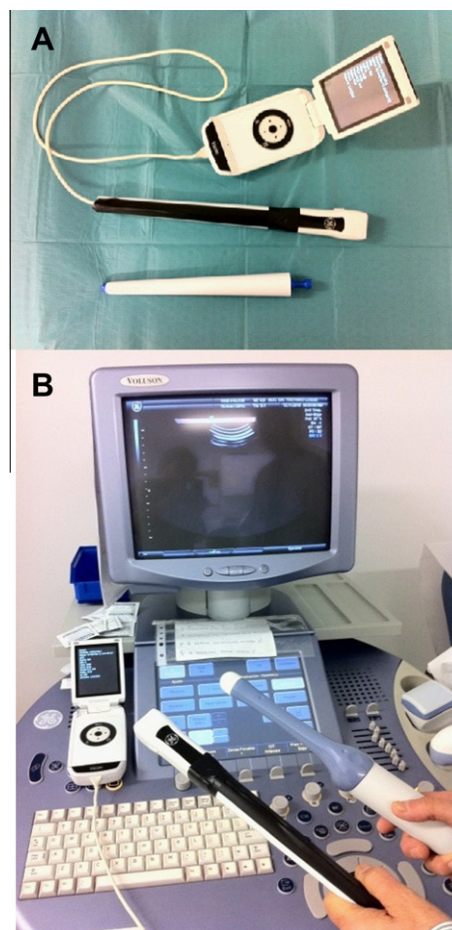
Transvaginal system TTGP-2010[®] ultrasound probe mounted and connected to the hand-held US device and comparative views Vscan versus V730-E.
